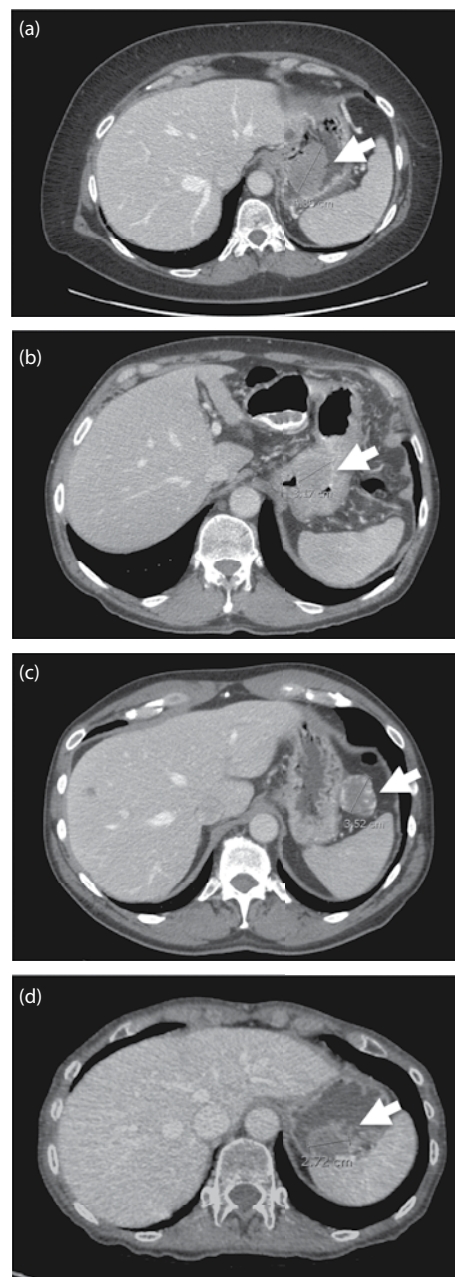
Benign and malignant nonadenomatous gastric tumors have similar appearance on CT scans. (a) Leiomyoma. (b) Schwannoma. (c) Hemangioma. (d) Gastrointestinal stromal tumor (GIST). White arrows indicate tumors.
